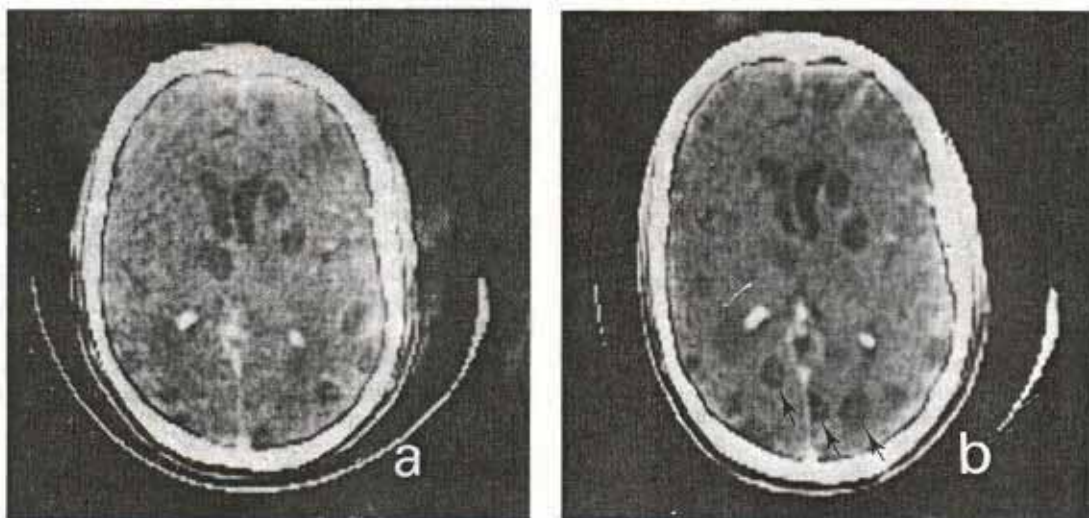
Follow-up Contrast CT Scans of a Control Patient with Multiple Parenchymal Cysts (Patient 2, Table 2), Showing the Natural Evolution of this Form of Neurocysticercosis.
